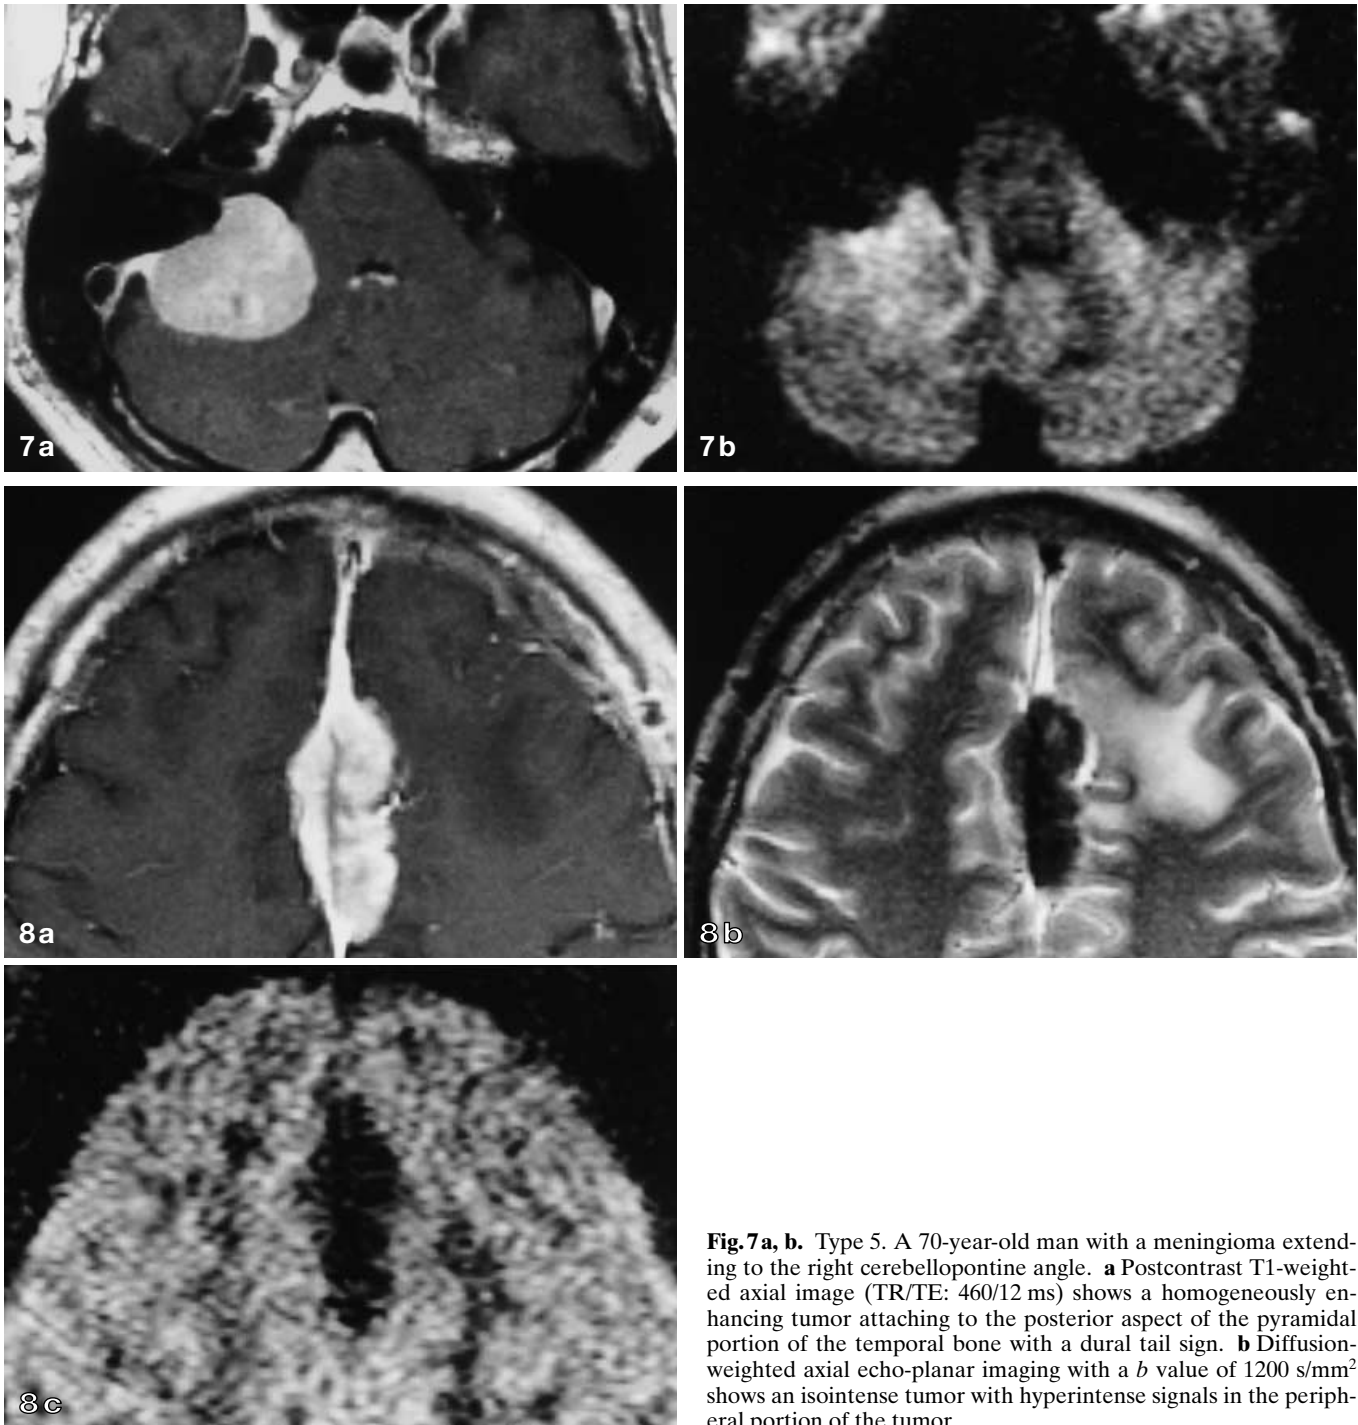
Type 5. A 70-year-old man with a meningioma extending to the right cerebellopontine angle. a Postcontrast T1-weighted axial image (TR/TE: 460/12 ms) shows a homogeneously enhancing tumor attaching to the posterior aspect of the pyramidal portion of the temporal bone with a dural tail sign. b Diffusion-weighted axial echo-planar imaging with a b value of 1200 s/mm² shows an isointense tumor with hyperintense signals in the peripheral portion of the tumor
